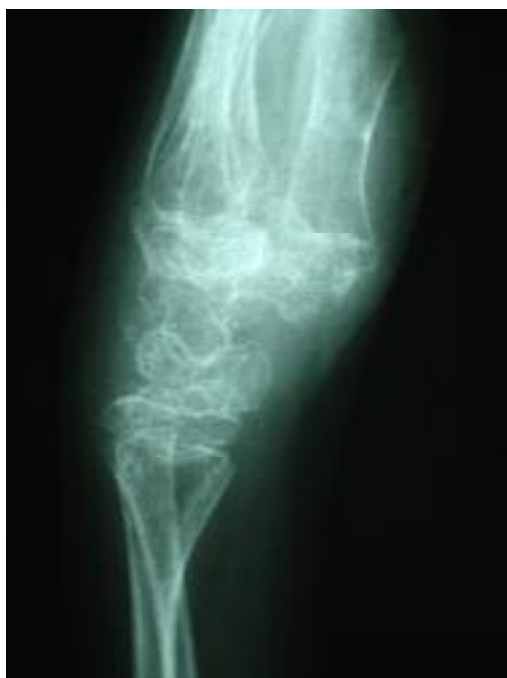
Lateral X-ray of the left wrist three months post surgery
